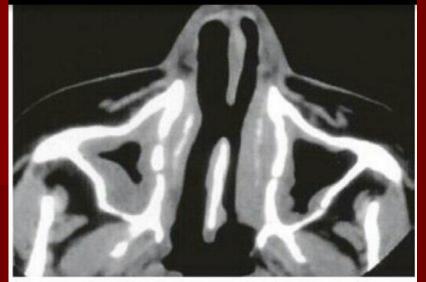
Computed tomography scan of the sinuses, showing sinusitis and destruction of the nasal septum.
